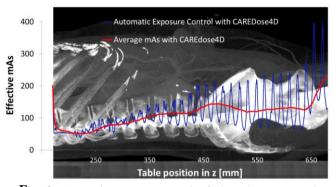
Automatic exposure control of the tube current using CAREDose4D from a patient undergoing a chest-abdomen-pelvis CT exam. The tube current continuously changes as a function of patient's attenuation; hence it follows changes angularly and longitudinally, in addition to real-time feedback (every half rotation) to fine tune the tube current applied to the patient.
